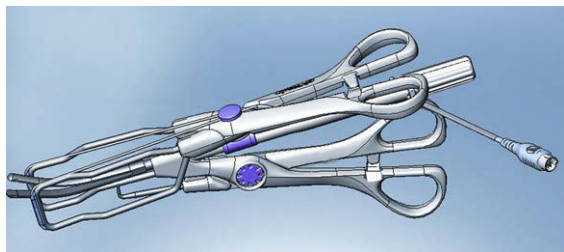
Uterine artery clamp used for Doppler-guided Uterine Artery Occlusion.
